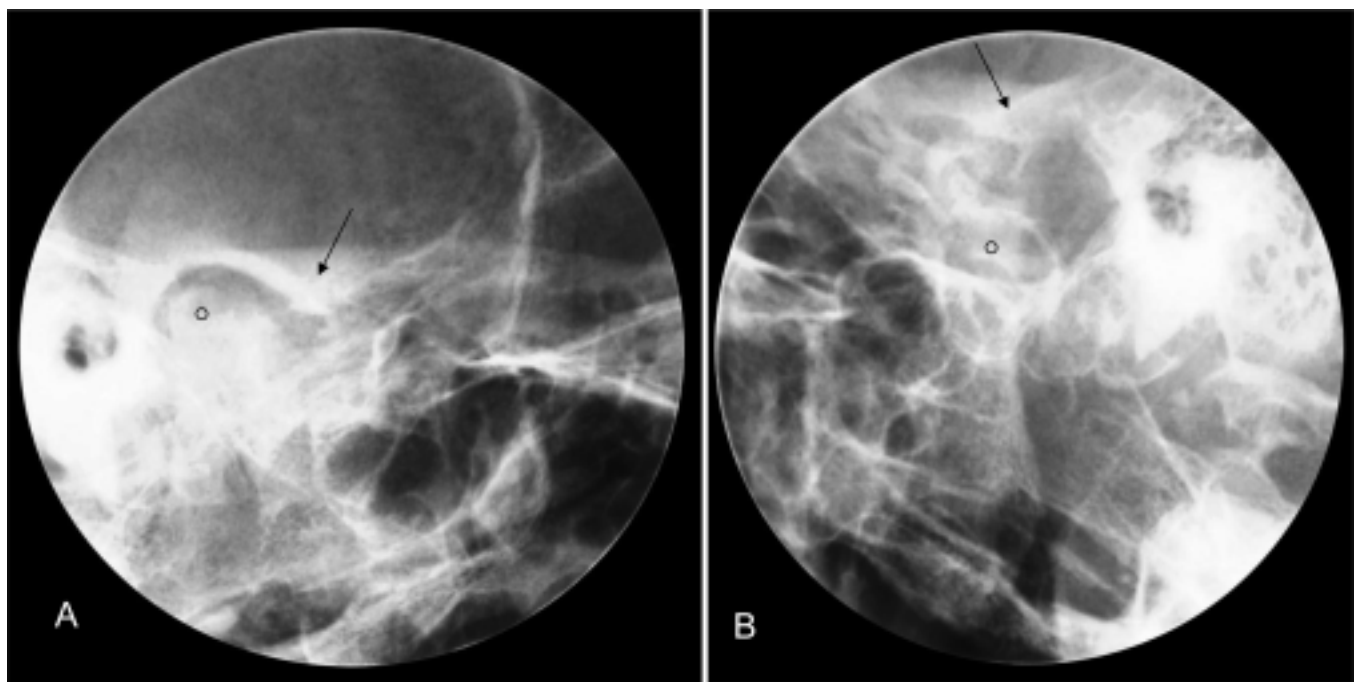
Postoperative radiographs taken five months later. (A) The right condylar process (○) is in the right position (arrow indicates the articular tubercle). (B) The left condylar process (○) is located beneath the articular tubercle.
